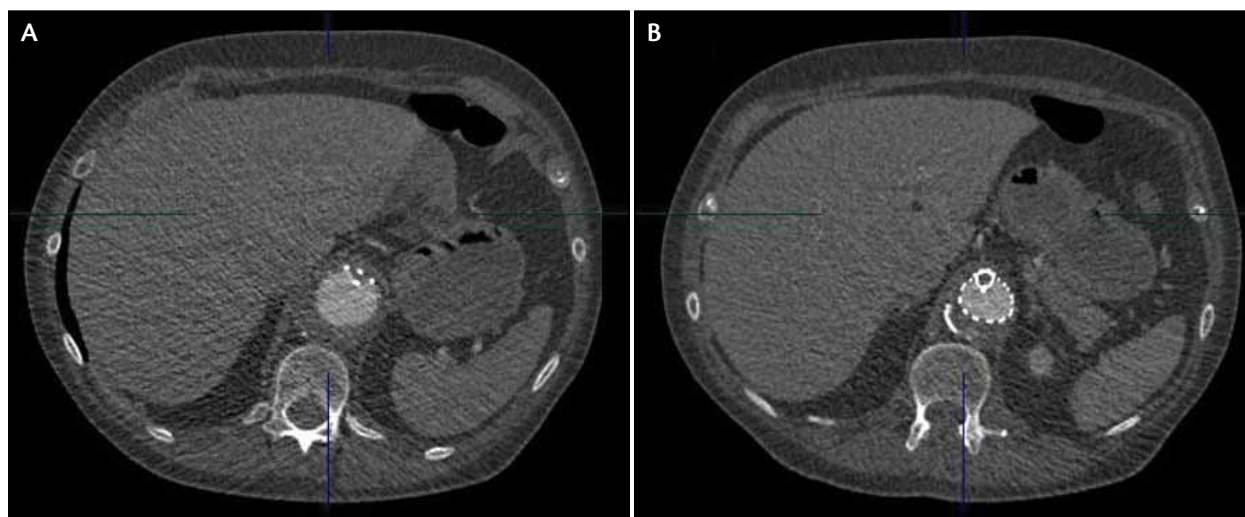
Axial CT scan showing an occluded celiac trunk branch (A) and SMA stent (B).
